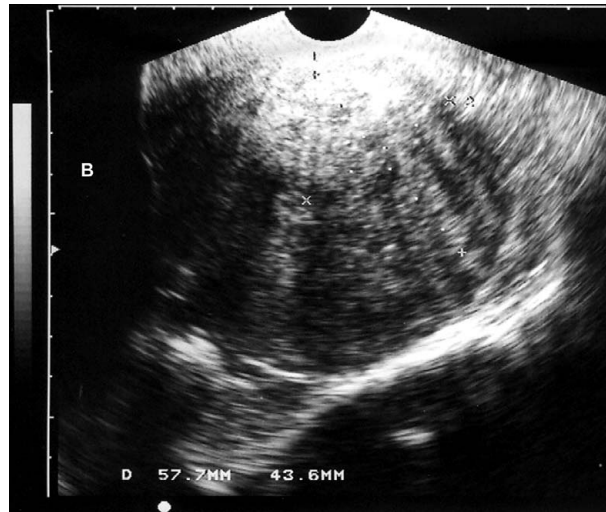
Transvaginal ultrasonography revealing a 5.7 × 4.3 cm posterior myoma compressing the lower portion of the bladder.
